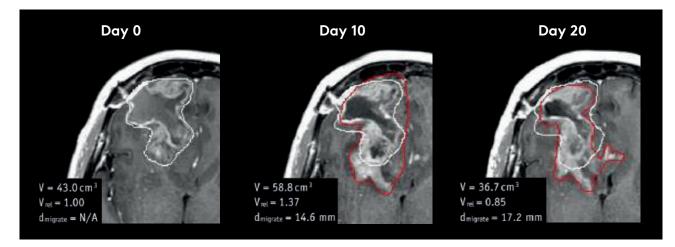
Brain tumor migration, not visible on CT, is apparent at day 10 and day 20 using MR imaging on Elekta Unity. MR images adapted from Stewart et al. 2021 and courtesy of Chia-Lin Tseng.
